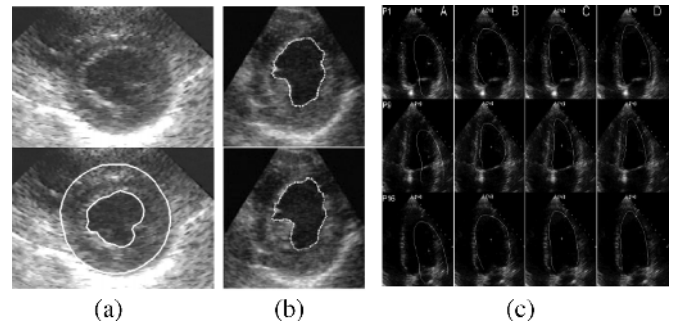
Examples of echocardiographic image segmentation. Short axis images from (a) Dias and Leitão [11] and from (b) Mikic *et al.* [12]. (c) Long axis images from Bosch *et al.* [13].
